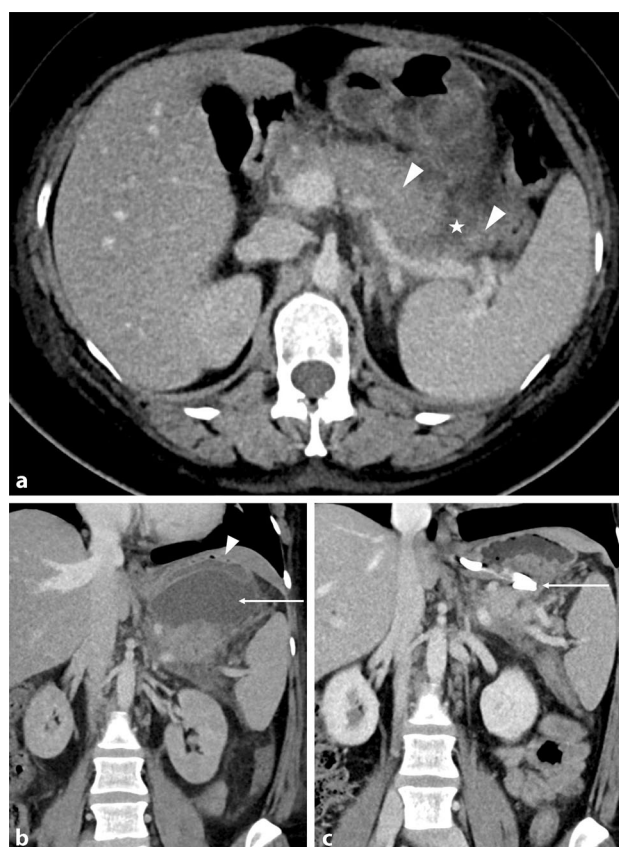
Axial contrast-enhanced abdominal computed tomography (CT) on the day of admission (a) shows a necrotizing pancreatitis with enlarged edematous pancreas (*arrowheads*) and nonenhancing areas in the cauda pancreatis, indicating parenchymal necrosis (*asterisk*). Coronal contrast-enhanced CT image after 10 days shows a large acute necrotic collection (*arrow*) in the lesser sac (*arrowhead*: stomach) (b). Postprocedural coronal contrast-enhanced CT image shows successful decompression (*arrow*) of the collection after transgastric drainage (c)
